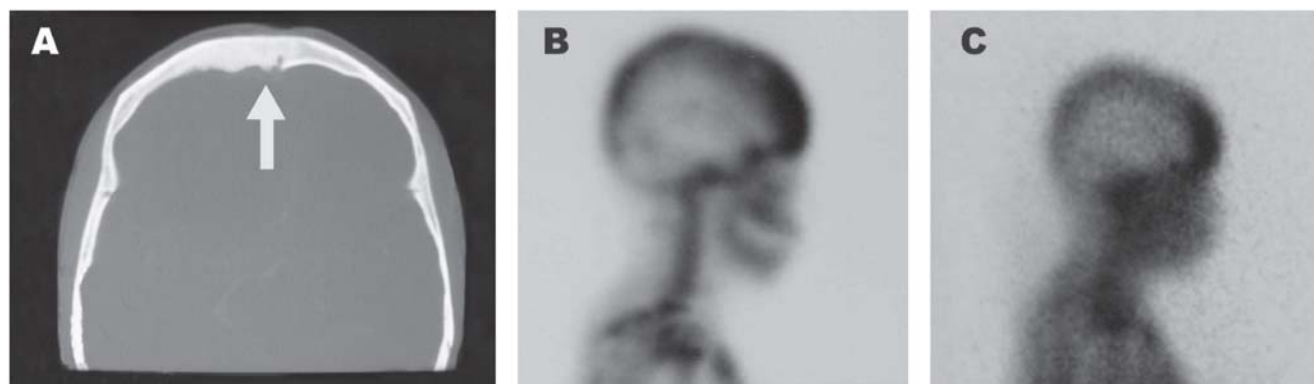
Sinus CT-scan with frontal inflammatory process (A) and scintigraphy with inflammatory activity and osteomyelitis with ^{99m}Tc (B) and ^{67}Ga (C).
